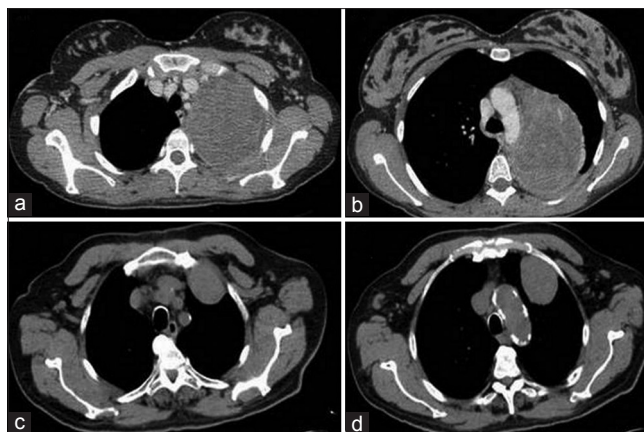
Case 1 - Chest CT scans at the left pulmonary apex level (a) and at the aortic arch level (b); Case 2 - Chest CT scans performed for biopsy show an intraparenchymal neoplasm near the anterior chest wall (c) and at the aortic arch level (d)
